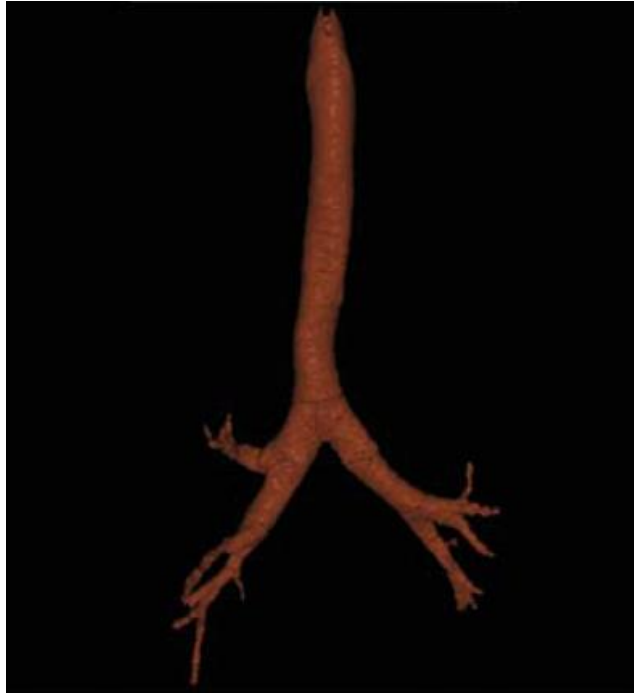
Human upper airways structure, segmented from a HRCT scan. Taken from [22].
